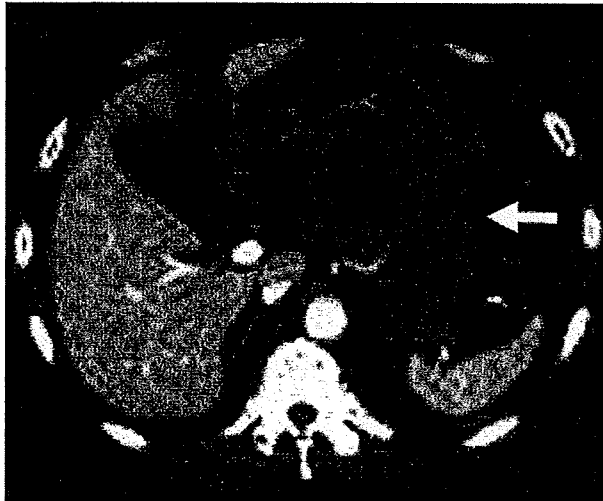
Contrast-enhanced computed tomography (CT) scan shows extensive ascites in the omental bursa and around the transverse mesocolon (arrow)
